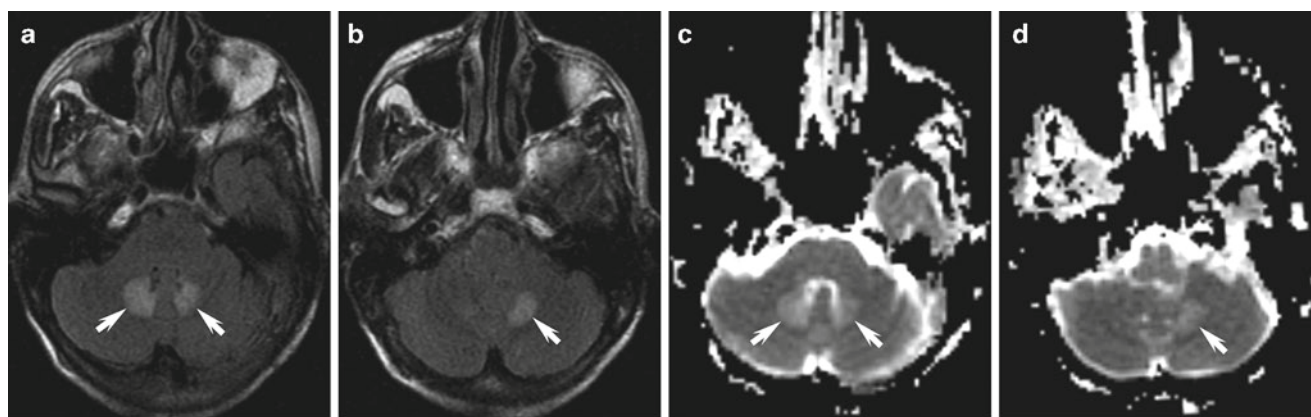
Metronidazole-induced encephalopathy. (a, b) Axial FLAIR and (c, d) ADC images demonstrate bilateral symmetric FLAIR hyperintensity involving the cerebellar dentate nuclei. On the ADC map, the lesions are hyperintense consistent with elevated diffusion. The lesions
